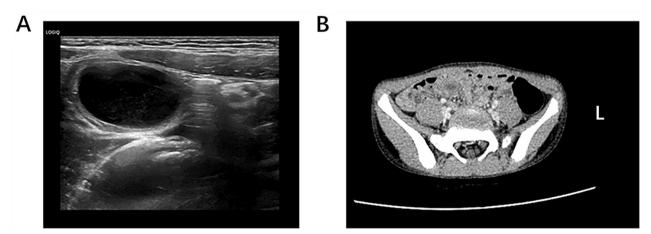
The results of imaging examination of the patient. A B-ultrasound showed that there was no echo mass in the right lower abdomen. B Computed tomography showed a mass of low-density focus in the right lower abdomen
